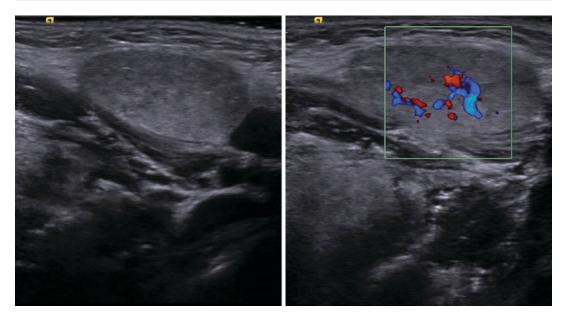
Dermoid Cyst. US reveals a superficial, oval-shaped, unilocular, isoechoic lesion with well-defined borders and mild vascularization on Doppler image
